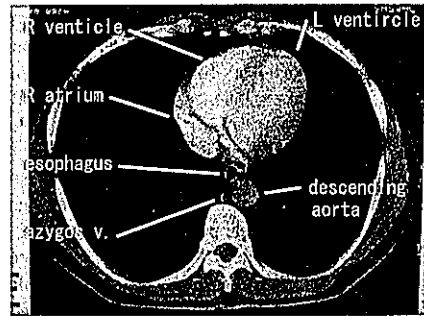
Autopsy imaging, CT, slice #20, control
